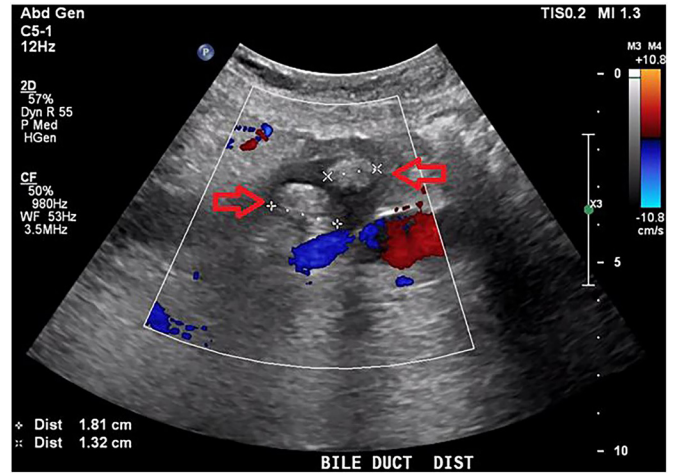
Abdominal ultrasound scan showing two gallstones in the distal common bile duct measuring 1.81 cm and 1.32 cm (red arrows).
